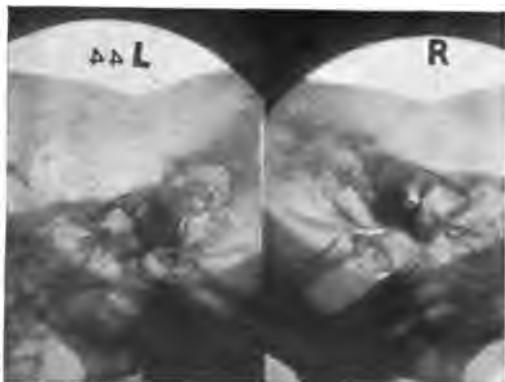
ROENTGENOGRAM OF SKULL NO. 44 AS SHOWN IN FIGS. 8 AND 9.
